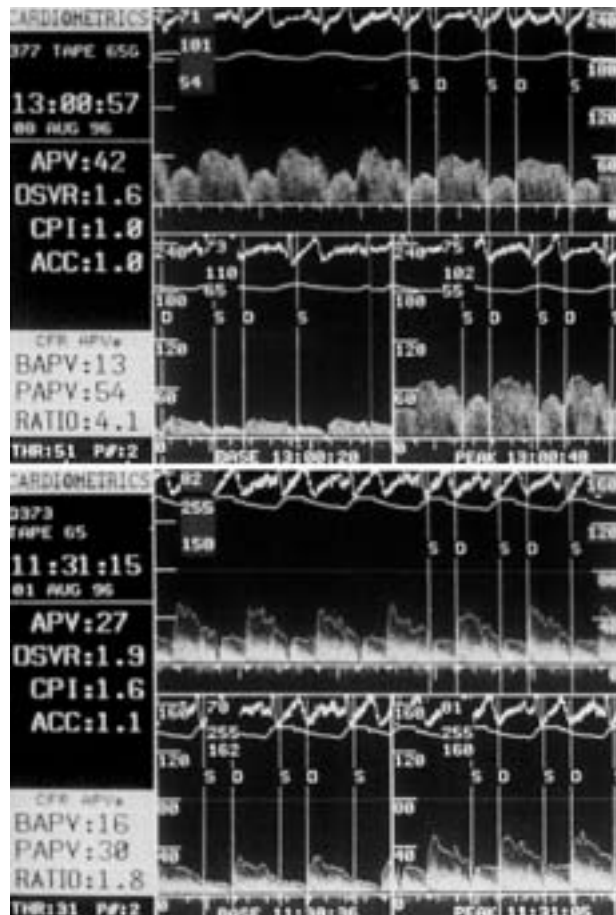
Intracoronary Doppler display representing intracoronary flow velocity in response to intracoronary adenosine for the evaluation of coronary flow reserve, which is calculated as the ratio of the peak velocities at maximal hyperemia divided by the baseline velocities. Top image: normal response to intracoronary adenosine with a coronary flow reserve of 4.1. Bottom image: abnormal coronary flow reserve of 1.8.
